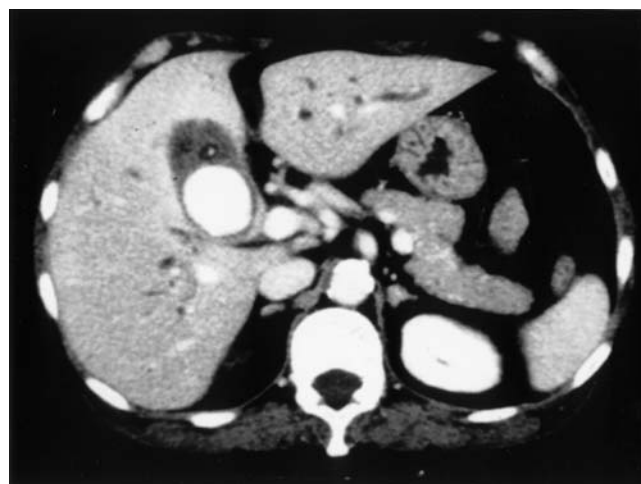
Contrast-enhanced computed tomography (CT), demonstrating a 3-cm pseudoaneurysm in the distended gallbladder
